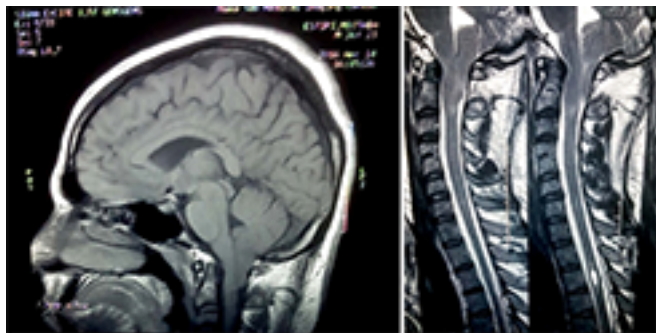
Sagittal T1 brain and T2 cervical MRI.
